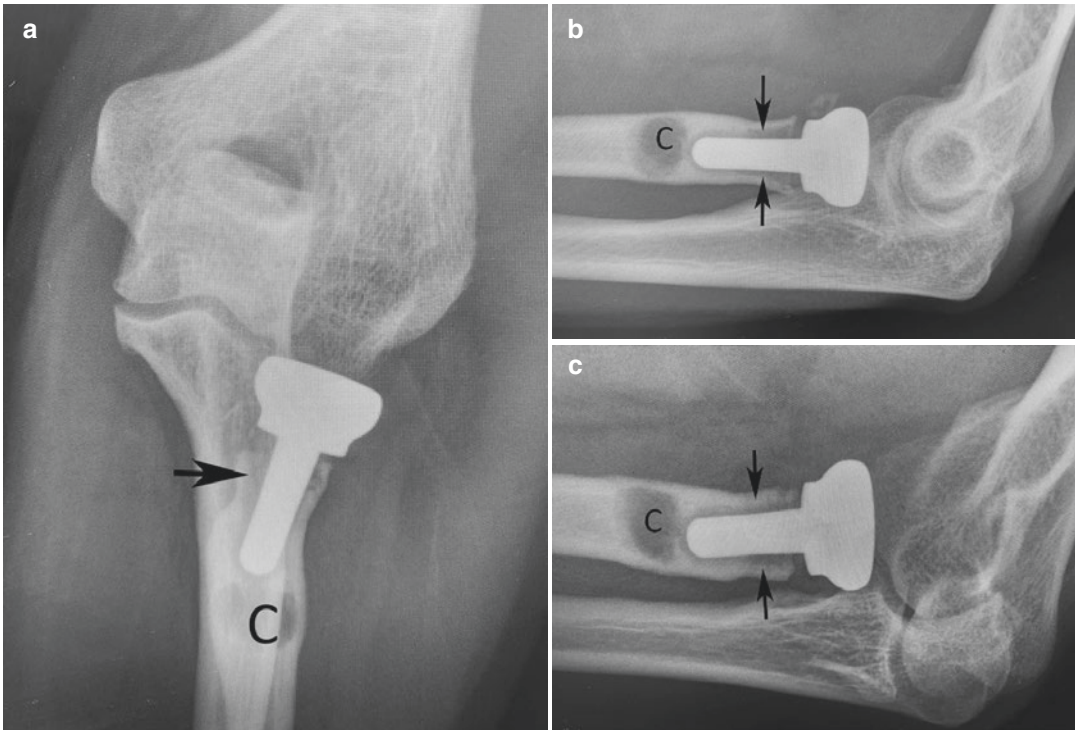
(a–c) Anteroposterior (a), lateral (b), and oblique (c) radiographs of the elbow with loosening of a press-fit radial head implant. Note the area of lucency
